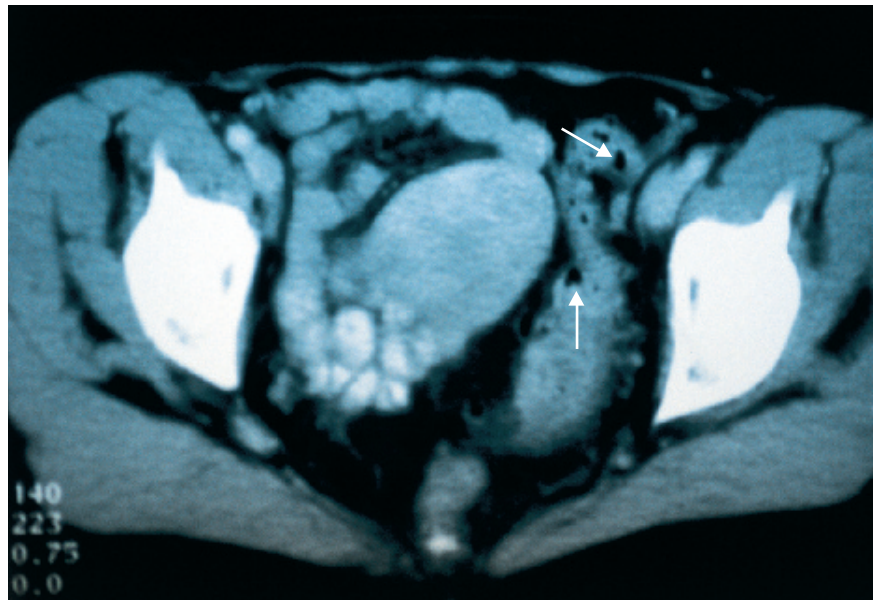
CT scan. The diverticula are seen as gas-filled pockets (arrows) outside the bowel lumen.
